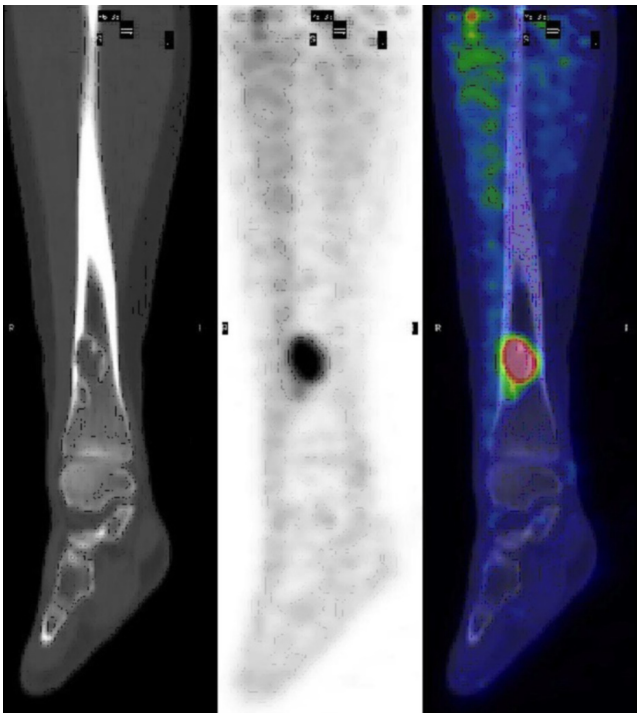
14-year-old girl with nonossifying fibroma. Lucent lesion is noted in the distal right tibia on sagittally reformatted CT (left). Increased uptake is noted in this lesion on coronal F18-FDG PET (middle) and F18-FDG PET/CT fusion image (right).
